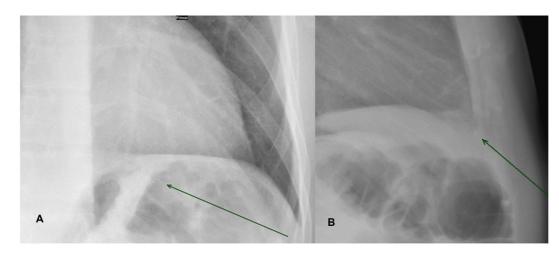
X-ray with the shard of metal in the right ventricular apex (green arrow). (A) Anterior-posterior view. (B) Lateral view.
